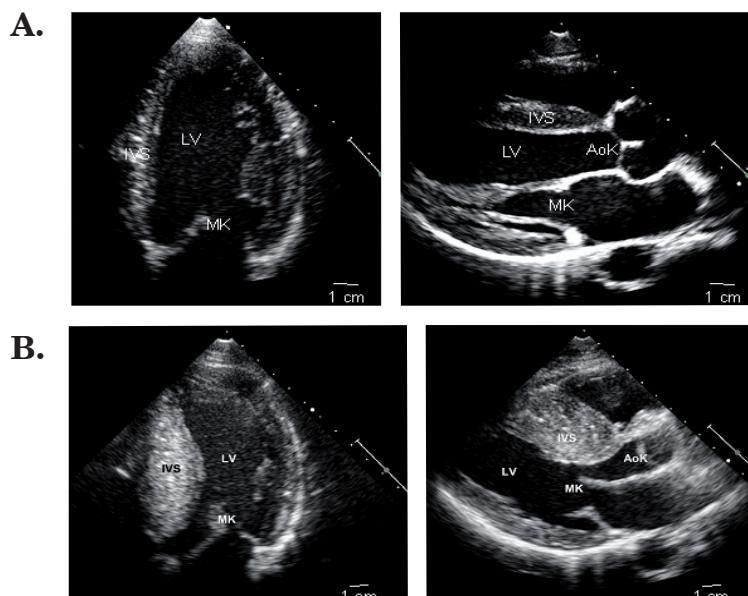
Echocardiographic images from a healthy person and a hypertrophic cardiomyopathy patient. On the left a four-chamber view focussed on the left ventricle and septum. The septum of a HCM patient (B) is considerably thicker than the septum of a healthy control (A). On the right a parasternal long axis view, visualizing outflow tract obstruction by the hypertrophied septum in a HCM patient (B). In healthy persons (A) the septum does not occlude the outflow tract from the left ventricle to the aorta. IVS indicates interventricular septum; LV, left ventricle; MK, mitral valve; AoK, aortic valve. Pictures by courtesy of Dr. F.J. ten Cate, Erasmus Medical Center Rotterdam, the Netherlands.
